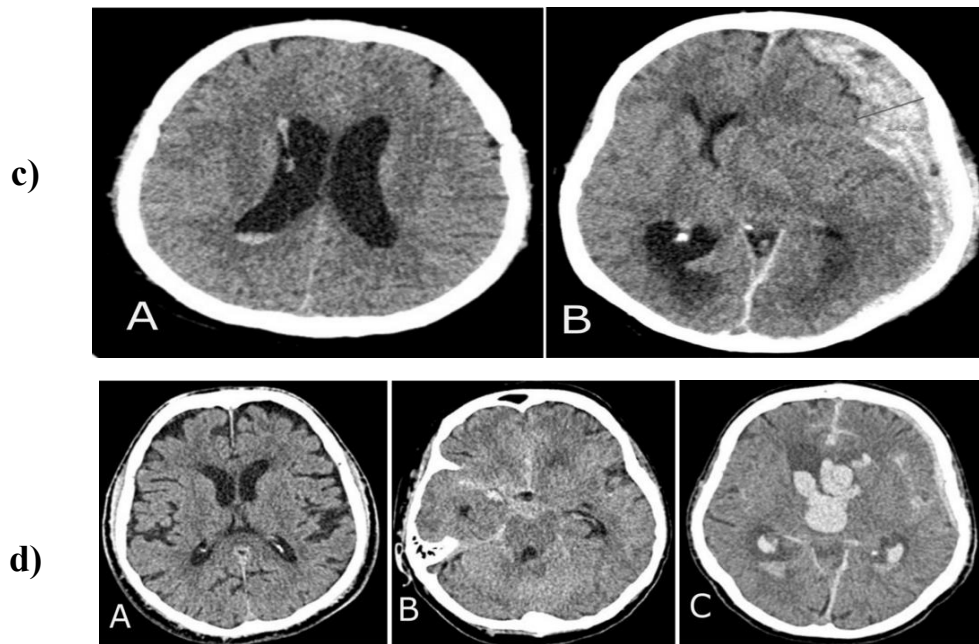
a) CT normal findings of basal cisterns (A); compressed B); absent (C), b) Midline shift normal findings (A); midline shift ≤ 5 mm (B); midline shift > 5 mm (C), c) Epidural space normal findings (A); epidural mass lesion acute epidural hematoma (B), d) Intraventricular and subarachnoid space normal findings (A); subarachnoid hemorrhage (SAH) (B); intraventricular hemorrhage (IVH) and SAH (C)
